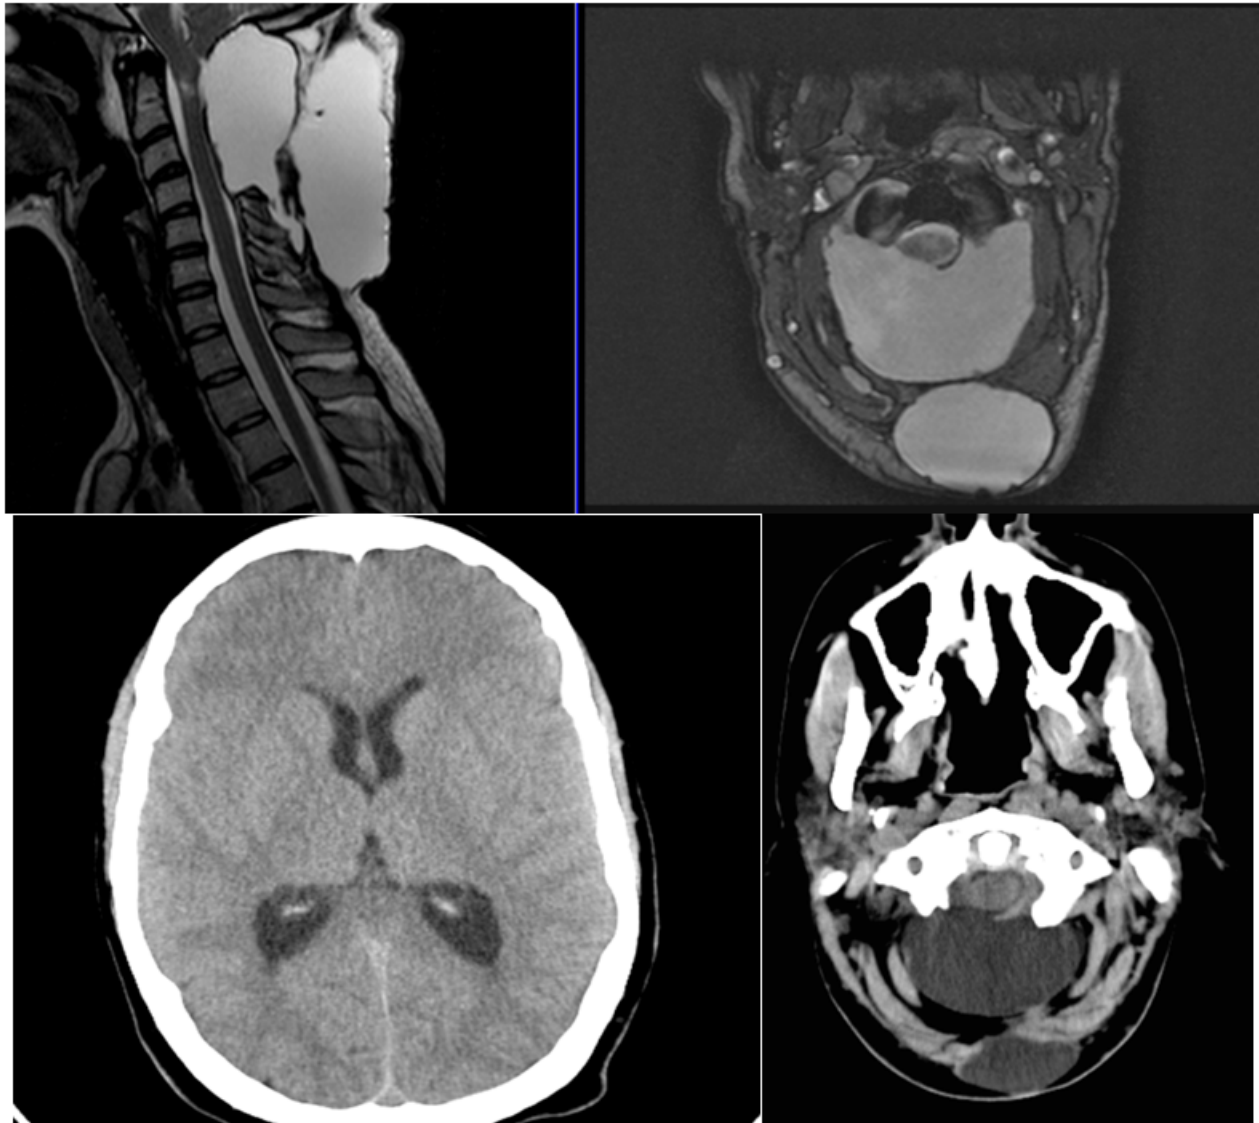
MRI and CT scan showing huge, postoperative pseudomeningocele, no signs of hydrocephalus, no signs of residual tumors.
